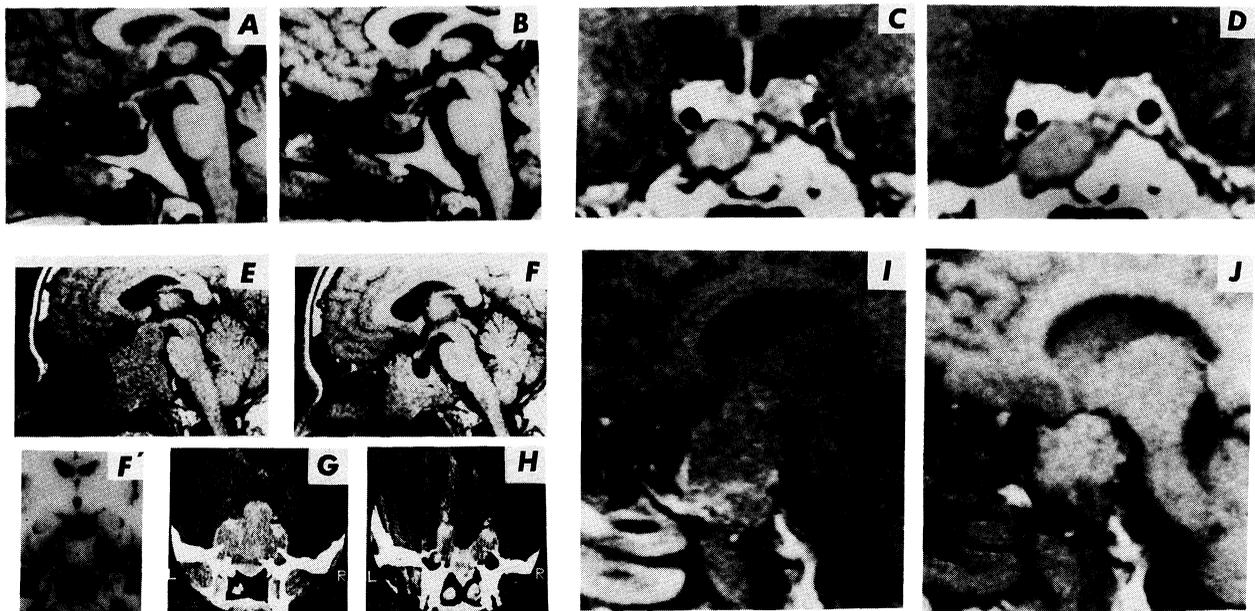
MRI and CT scans of TSH-secreting pituitary adenomas before and during treatment with octreotide. MRI before (A) and after (B) treatment for 8 weeks in case 1; MRI before (C) and after (D) treatment for 50 weeks in case 2; MRI before (E) and after (F) treatment for 4 weeks in case 3; CT scan after withdrawal of octreotide treatment for 4 weeks (G) and 2 weeks after reinstatement of octreotide (H) in case 3; MRI before (I) and after (J) treatment for 4 weeks in case 4.
